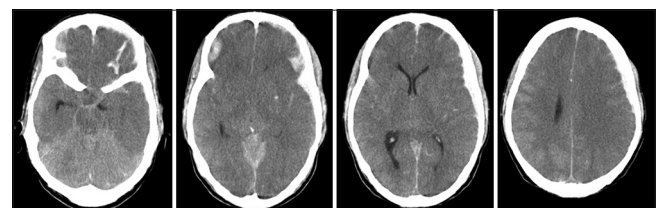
(Computed tomography scan) – Extensive subarachnoid hemorrhage seen in Basal cisterns, bilateral Sylvian fissures. Left frontal parietal subdural hemorrhage 6 mm in maximum thickness. Focal small hematoma seen in the region of left Sylvian fissure. Diffuse subdural hemorrhage seen extending along the tentorium. Mild mass effect seen on the left with subtle midline shift to the right by 4 mm
